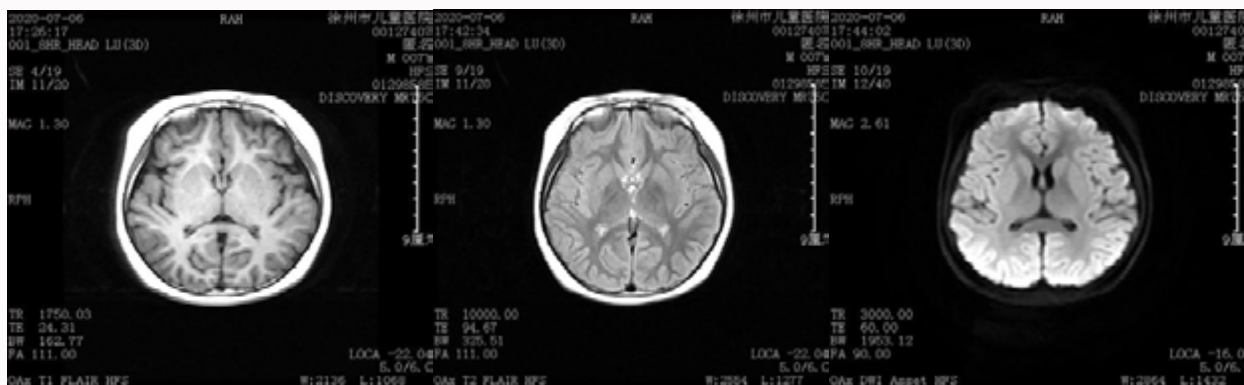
Brain MRI showed no abnormality after 3-week treatment.
